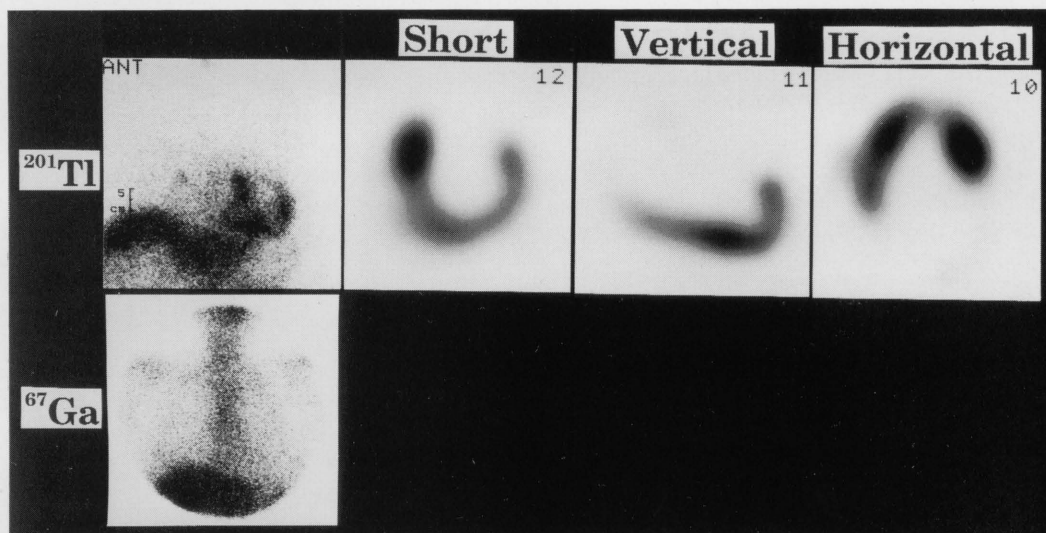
^{201}Tl and ^{67}Ga imaging after corticosteroid therapy. Disappearance of the abnormal uptake in hilar lymph nodes was shown in both ^{201}Tl and ^{67}Ga scintigrams.
